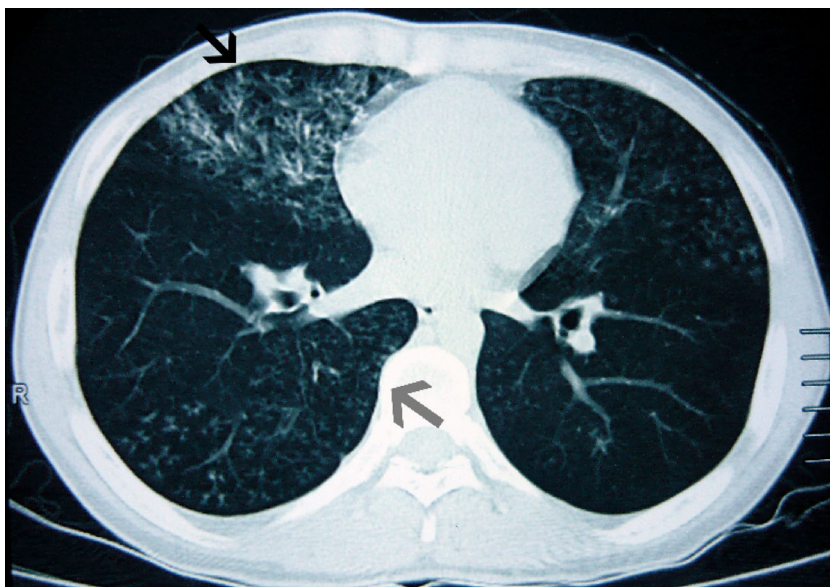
Chest high-resolution computed tomography showed bronchiectasis in the right middle lobe (black arrow) and multiple centrilobular micronodules in both lungs; the micronodules were predominantly distributed on the right side, forming the tree-in-bud structure (gray arrow).
